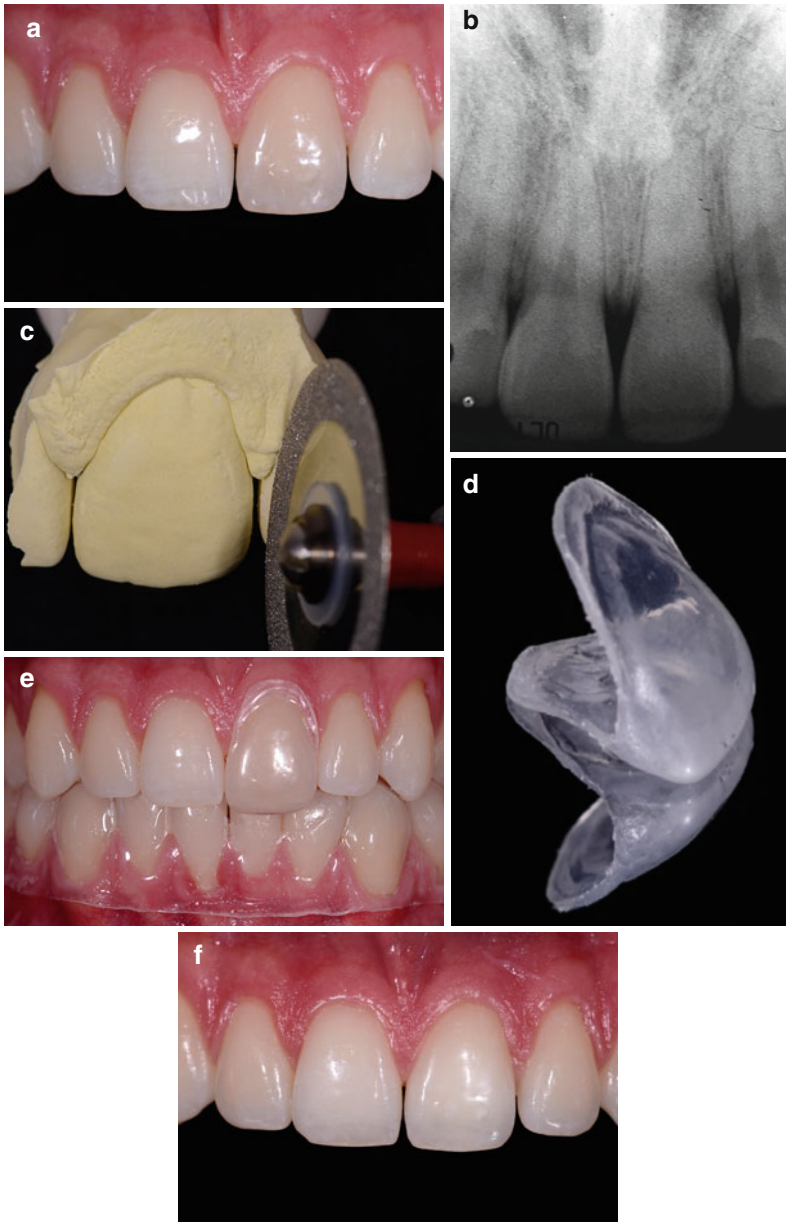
(a) A 25-year-old patient with discolored #9 (FDI 2.1). Patient had an accident when she was 21 years old. (b) After radiographic exam and clinical exam, the diagnosis was calcific metamorphosis. The tooth responded to cold stimulus applied from the lingual aspect. (c) and (d) A tray was fabricated to cover only the discolored tooth. (e) Single-tooth tray inserted onto tooth #9 (FDI 2.1) and the lower stabilizing tray to prevent the upper single tooth tray from dislodging. The lower tray was not used as a bleaching tray. (f) Clinical aspect after 3 weeks of daily whitening with 10% carbamide peroxide gel with potassium nitrate and sodium fluoride (Whiteness Perfect 10%, FGM) for 4 h daily. This patient had decided that she did not want to perform the treatment overnight
